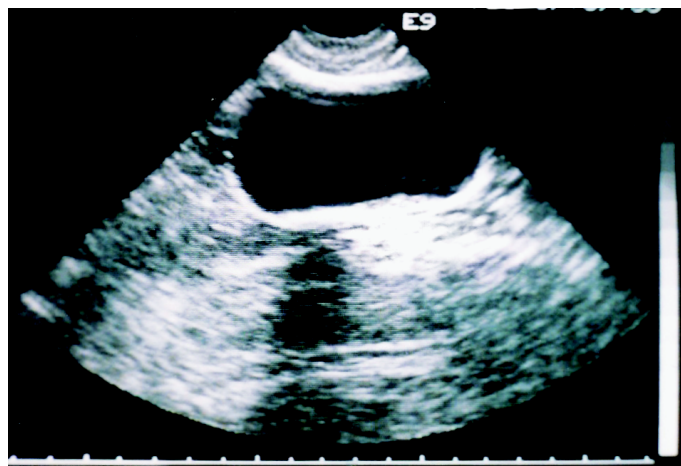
Sonographic imaging of urinal bladder in transverse plane
